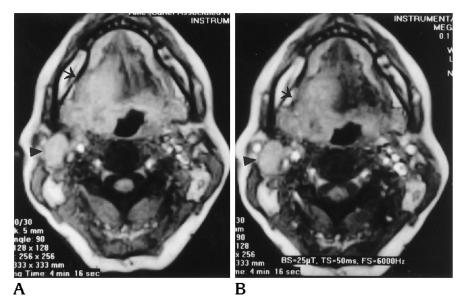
Axial T1-weighted 0.1-T MR images after administration of gadopentetate dimeglumine (250/30; flip angle, 90°) show squamous cell carcinoma of the tongue (arrows) with ipsilateral lymphadenopathy (arrowheads). The contrast between tumor and adjacent tongue muscle is better on the MT image (B) than on the non-MT image (A).
